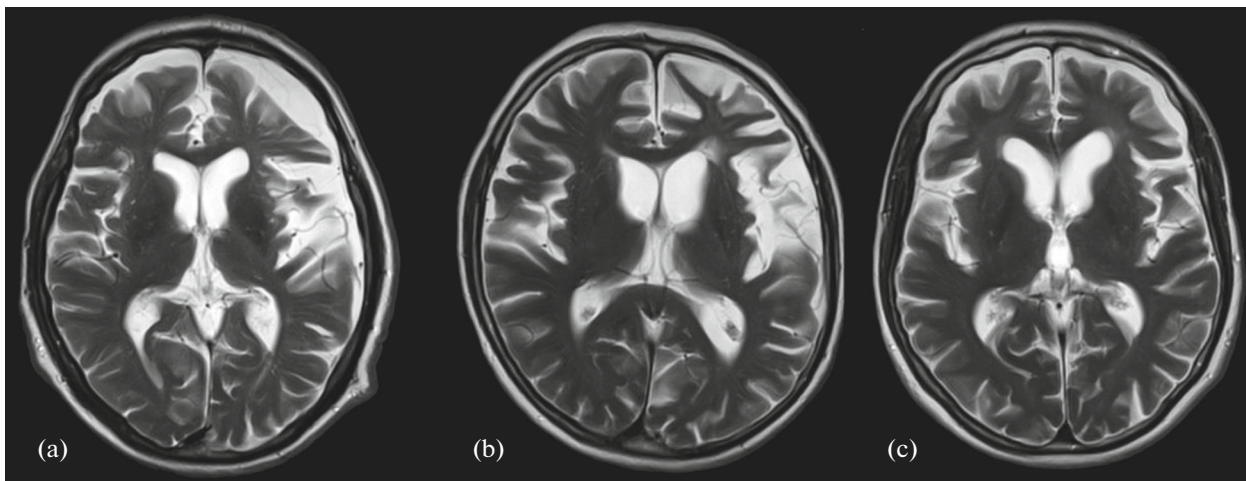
MRI of the brain with nvPPA (T2-weighted images). (a) nvPPA without pathogenic mutations in *C9orf72*, *MAPT*, *GRN* genes. (b) nvPPA associated with a mutation in *GRN* gene. (c) nvPPA associated with a mutation in *C9orf72* gene.
